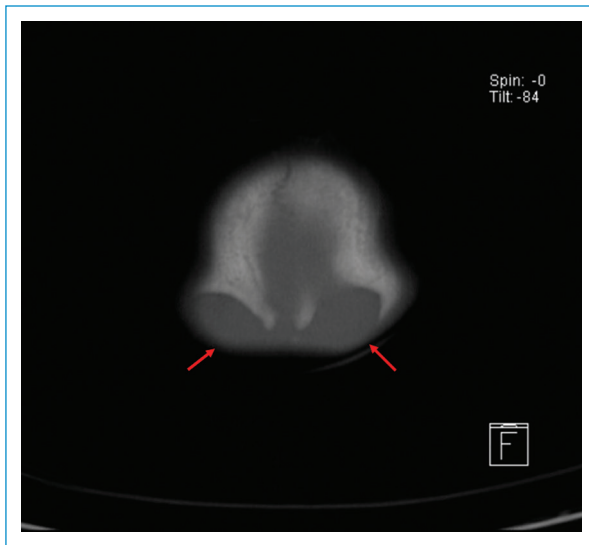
Bone window image of a cranial CT-scan demonstrating a bilobed bone (red arrows).
